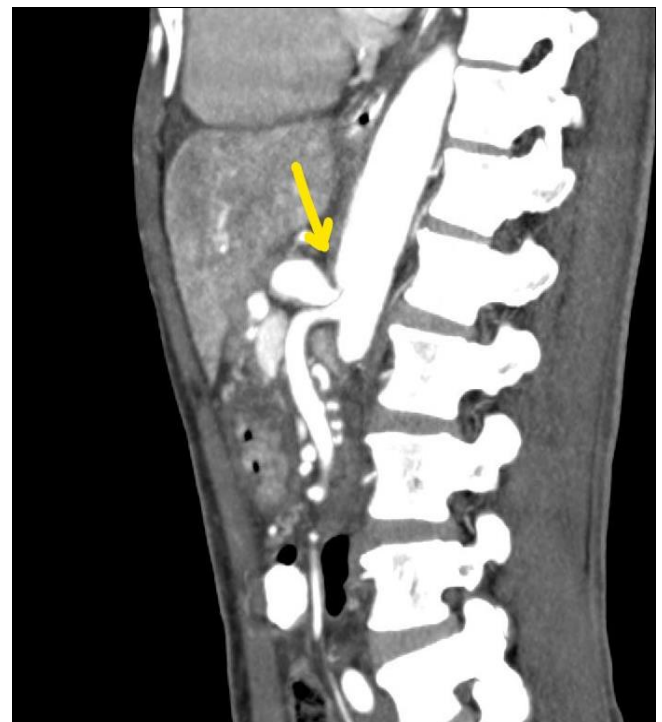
CT abdomen Angiography showing focal Narrowing (60-70%) of the superior aspect of the proximal celiac trunk
